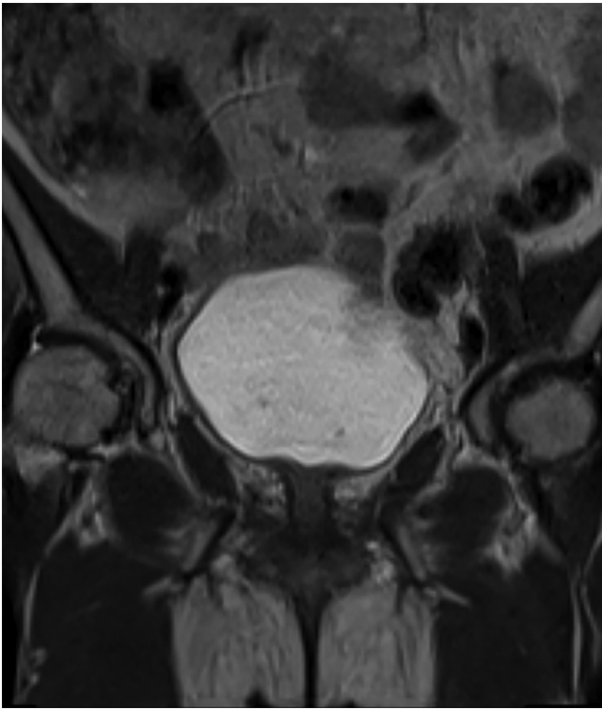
Magnetic resonance image captured 3 months after chemotherapy. No evidence of suspected regions of cancer was found after treatment.
